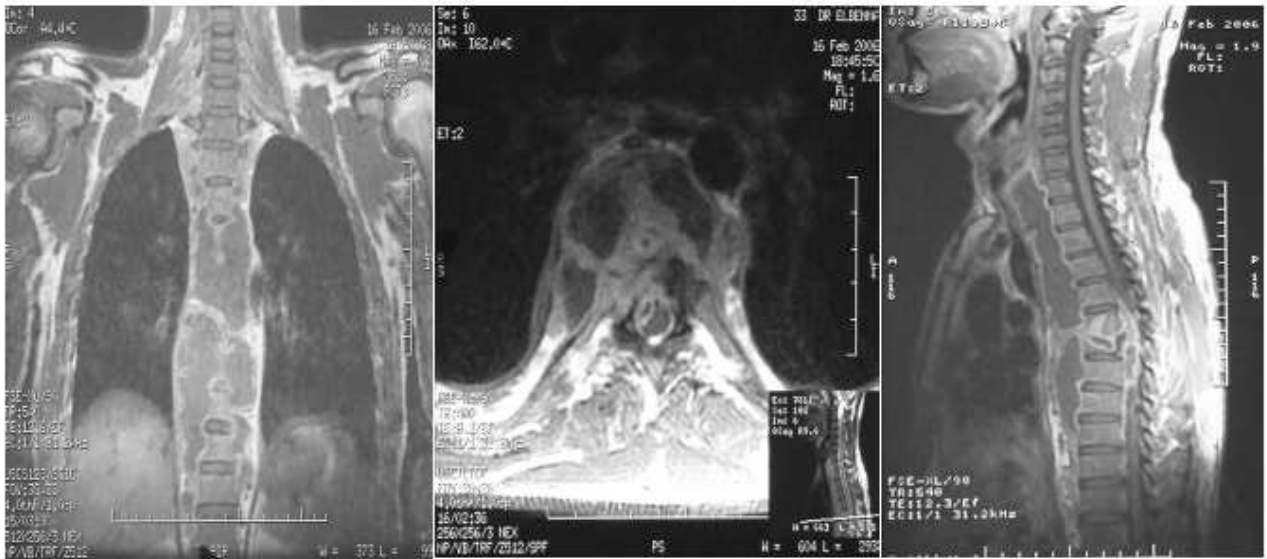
MRI chest: para- vertebral abscess with bone destruction of the vertebral body
